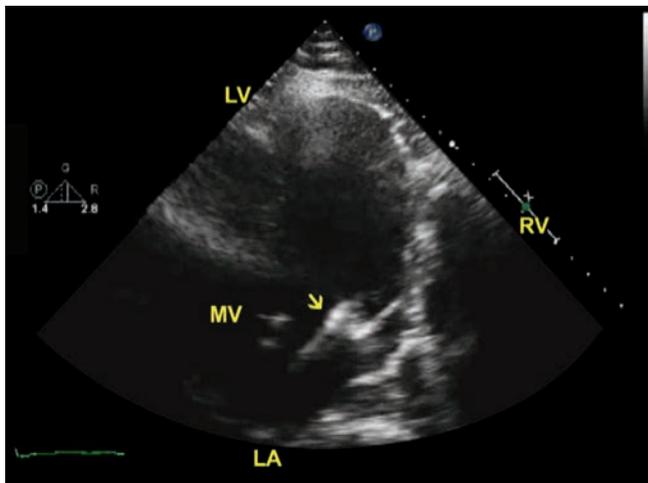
Transthoracic apical view. Arrow points to implantable cardioverter defibrillator lead going through the MV.
